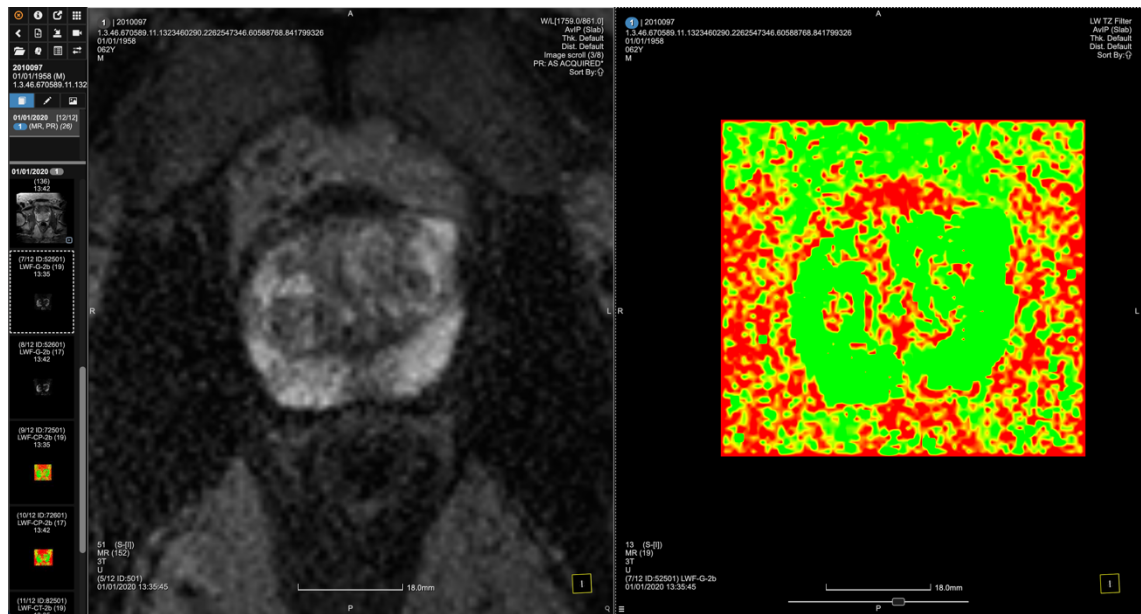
LI-MRI implementation on Biotronics3D suite.
